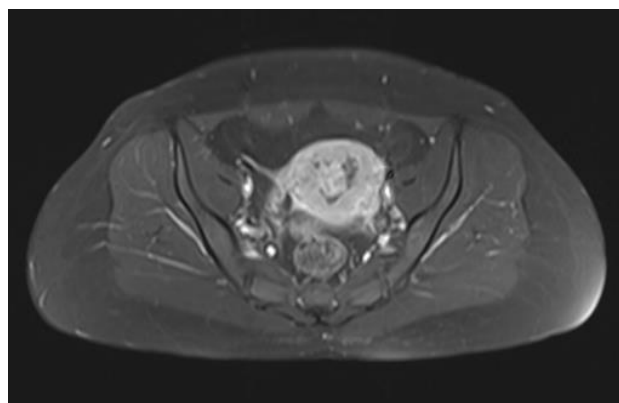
Axial T1 weighted fat saturated post contrast image of the MRI pelvis showing lobulated tortuous intensely enhancing lesion within the endometrial cavity.
